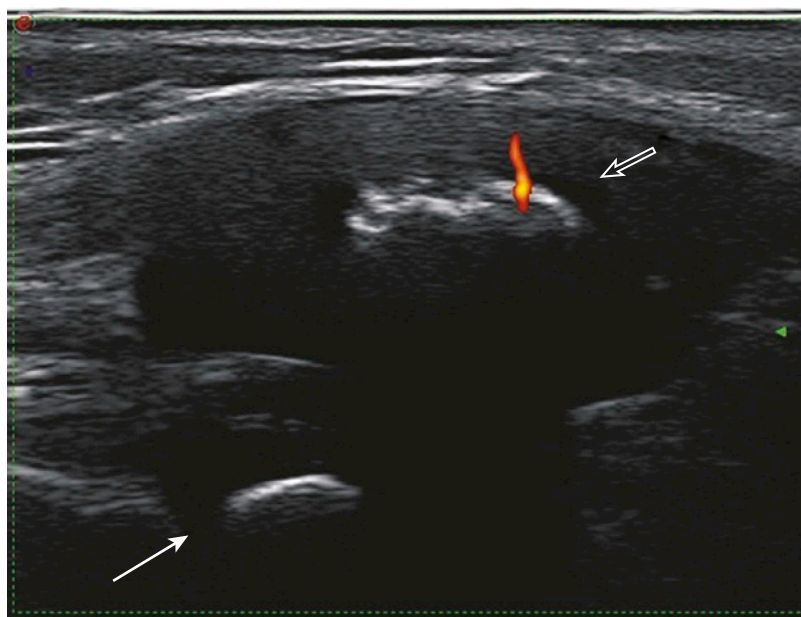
EPIPHYSEAL PLATE OF THE DISTAL FEMUR AND OSSIFICATION CENTER OF THE PATELLA. On ultrasound, the femoral epiphyseal or growth plate (*arrow*) of a 3-year-old child appears as a distinct cleft in the echogenic contour of the femur. The ossification center of the patella (*open arrow*) appears as a hyperechoic nucleus within the anechoic, unossified bone. A physiologic feeding vessel is seen entering the ossification center.
